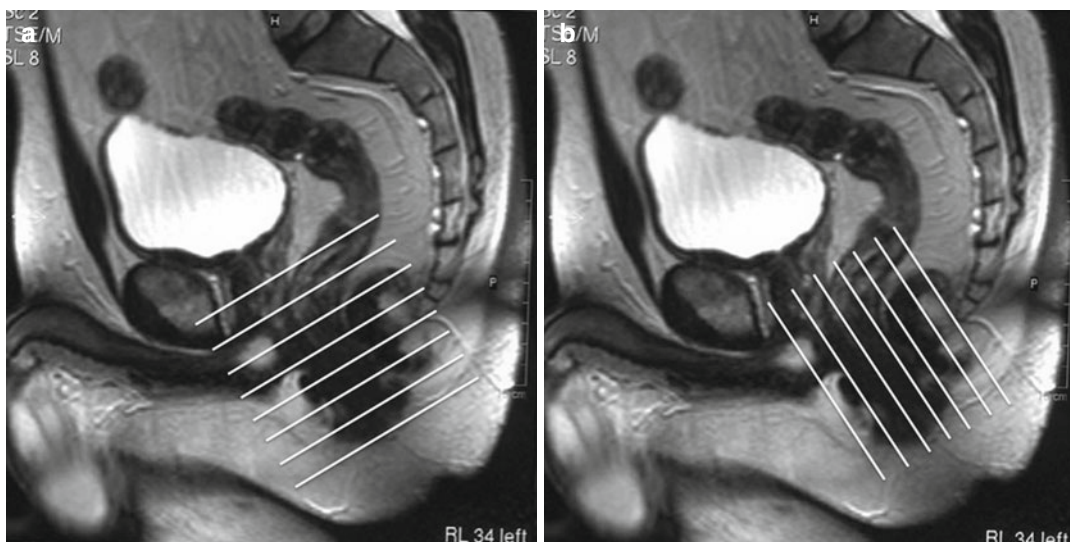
Sagittal T2-weighted planning scan showing the orientation of the anal canal and the oblique axis to which the axial (a) and coronal (b) scans must be aligned
